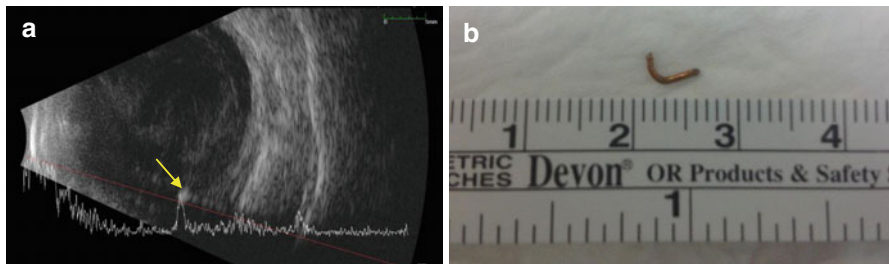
(a) B-scan ultrasonography of an eye with post-traumatic endophthalmitis suspicious for an intraocular foreign body; A-scan shows the foreign body as a hyperintense area with high reflectivity (yellow arrow) (b). The foreign body, a metallic nail measuring 4.5 mm, was later removed from the same eye
